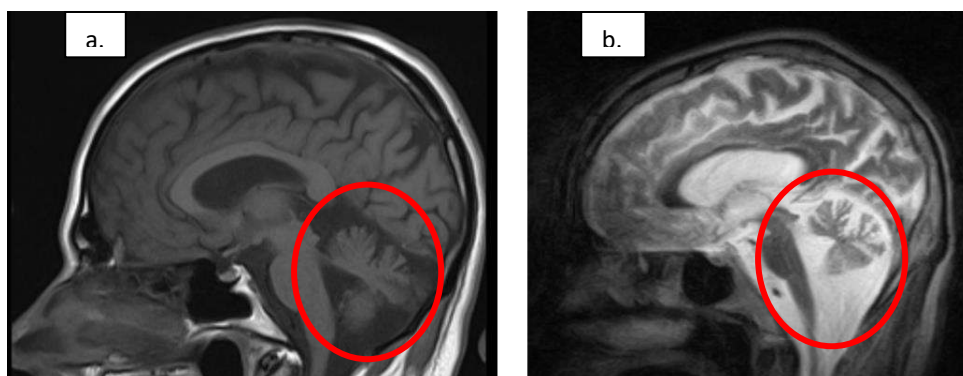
Cranial MRI sections showing cerebellar atrophy. a. P1 at the age of 35 b. P2 at the age of 48 in Family 3. Note that b. shows a more advanced stage of cerebellar atrophy.
